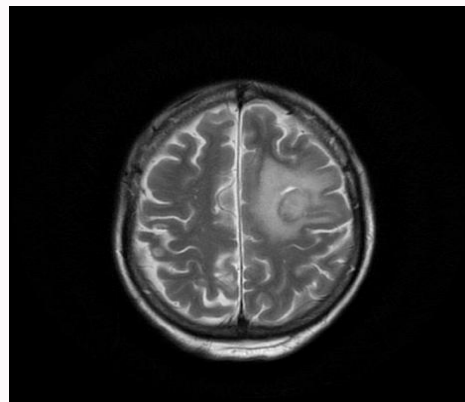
Sagittal view of MRI showing large nodular lesions with ring-enhancing, and perifocal oedema.
